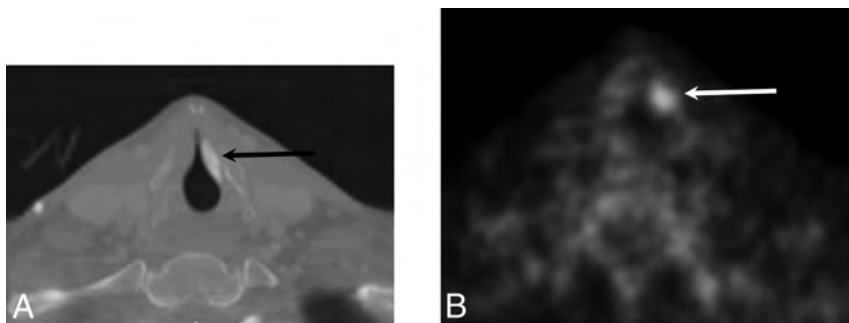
Calcium hydroxylapatite. A, Axial contrast-enhanced CT with a bone algorithm demonstrates hyperattenuating material in the region of the left vocal fold (black arrow). B, Axial positron-emission tomography demonstrates hypermetabolism at the site of the injected material, which can be a false-positive finding for malignant disease (white arrow).
